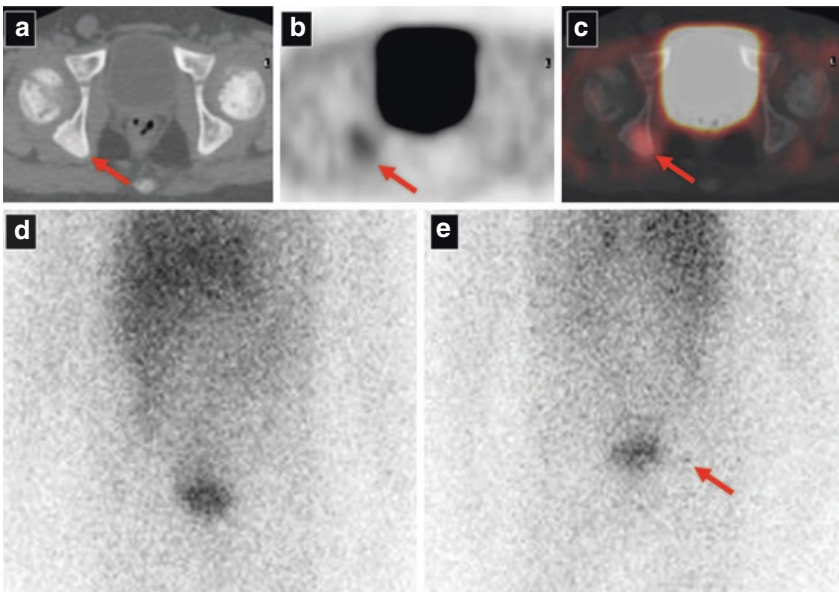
Example of a patient with recurrent NB showing a clear pathological uptake on the right ischial bone on ^{18}F -DOPA PET/CT (a–c: red arrows); on counterpart, there is only a faint uptake visible in the posterior view (e) in the ^{123}I -MIBG scintigraphy while undetectable on anterior projection (d)
